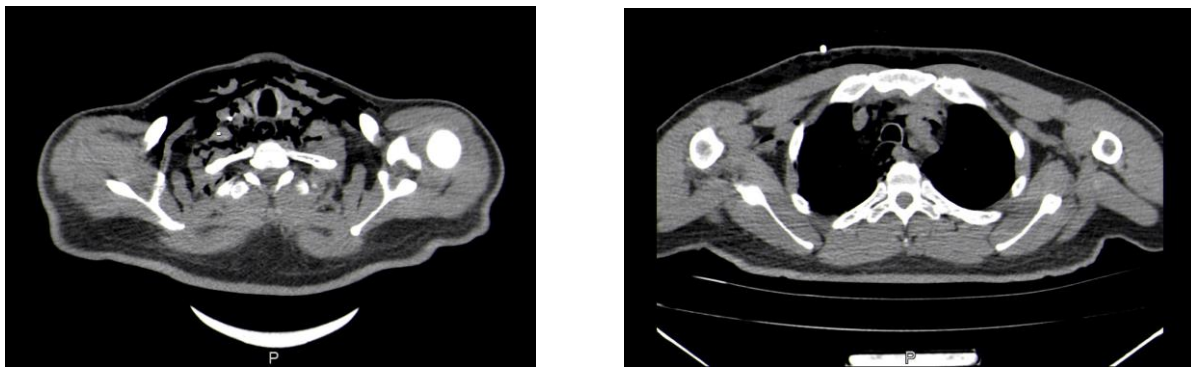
The cross section of the CT SCAN showed the subcutaneous emphysema of the neck.
